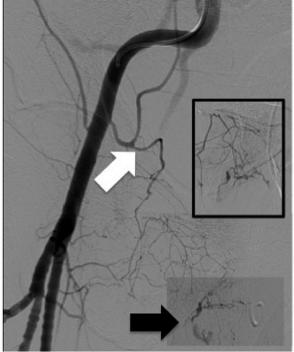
(a) CT scan shows hematoma over the right obturator canal (asterisk) and bilateral CM (curved arrows). The latter is in the typical location, crossing over the anterior lip of the acetabulum. Pubic rami fractures and diastasis of the right sacroiliac joint were present (not shown). (b) Right external iliac angiogram shows right CM with the aberrant right obturator artery (white arrow) arising from the right inferior epigastric artery. An area of extravasation over the superior pubic rami is noted (black arrow) and seen more clearly with superselective catheterization of the CM artery (inset). Embolization of the aberrant obturator artery was successfully performed (not shown).
